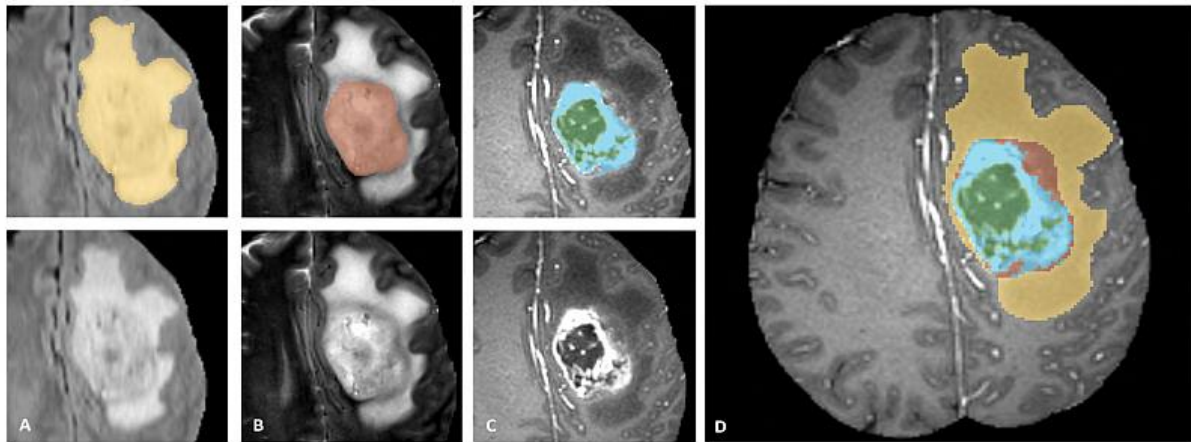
4 Glioma Images and tumor sub regions annotated using different MRI modalities (Top Left), and the final labels of the entire patient brain (Figure D). Glioma images show from left to right: the whole tumor in yellow shown using T2-FLAIR (Figure A), the tumor core in red shown using T2 (Figure B), the enhancing tumor structures in light blue) shown using T1Gd, surrounding the necrotic parts of the core (green) (Figure C) [27]
